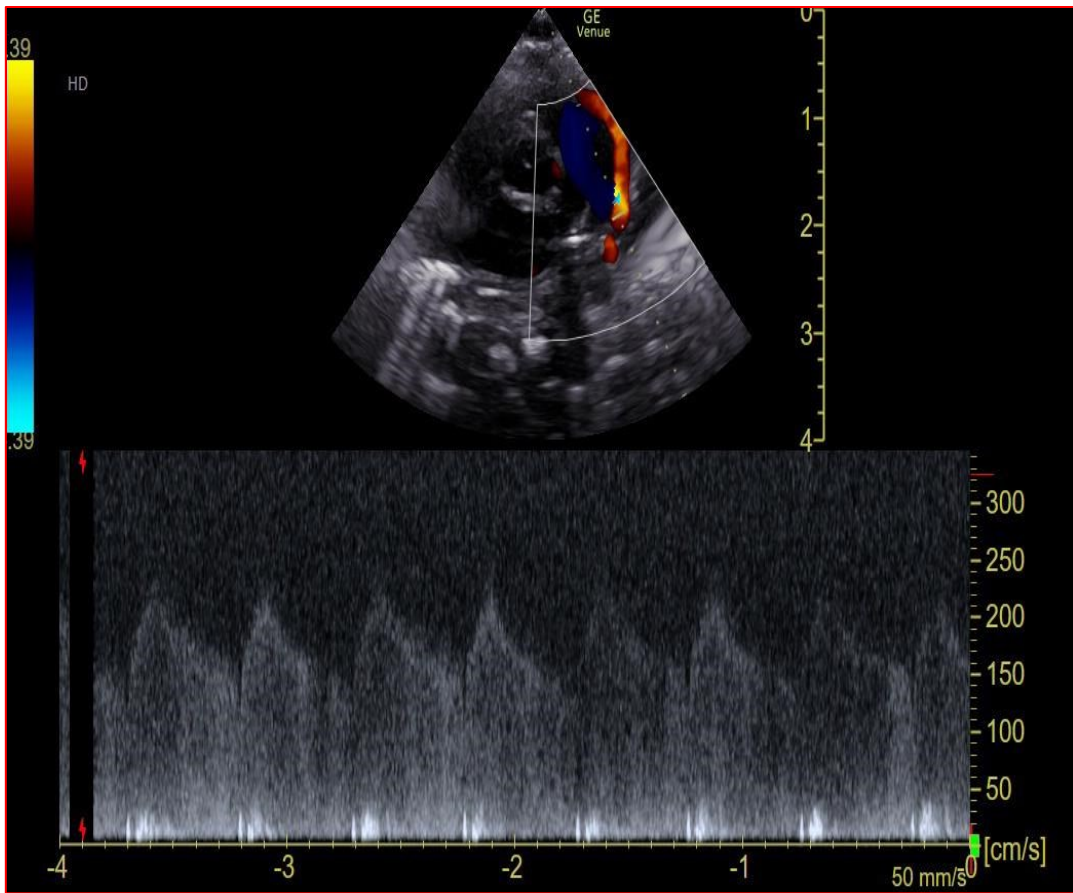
ultrasound DA detection and its pattern
